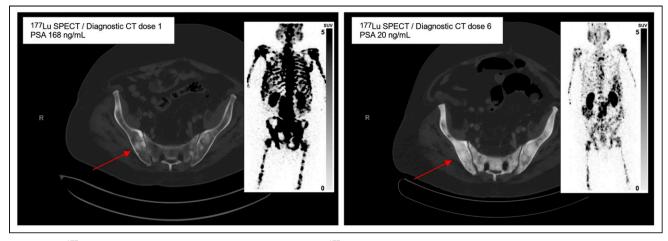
¹⁷⁷Lu-PSMA SPECT/CT images for 1 of 6 cases treated with ¹⁷⁷Lu-PSMA-I&T who developed hypocalcemia. Images within 24 h after dose 1 (left) and dose 6 (right) show significant reduction in cancer volume with concomitant marked osteosclerotic response (arrows).
